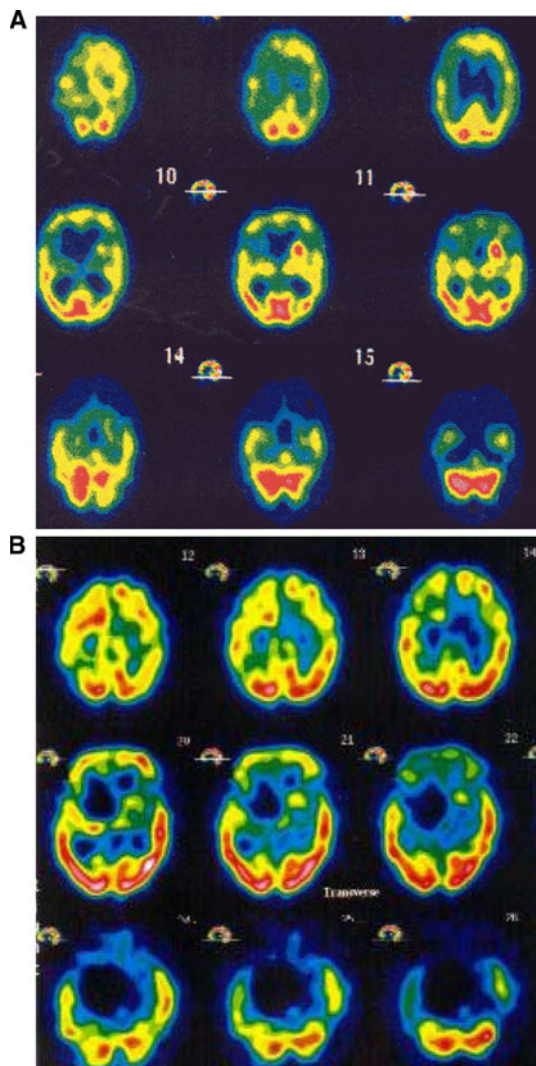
Functional imaging with SPECT before (a) and 6 months after vitamin B12 replacement (b)
